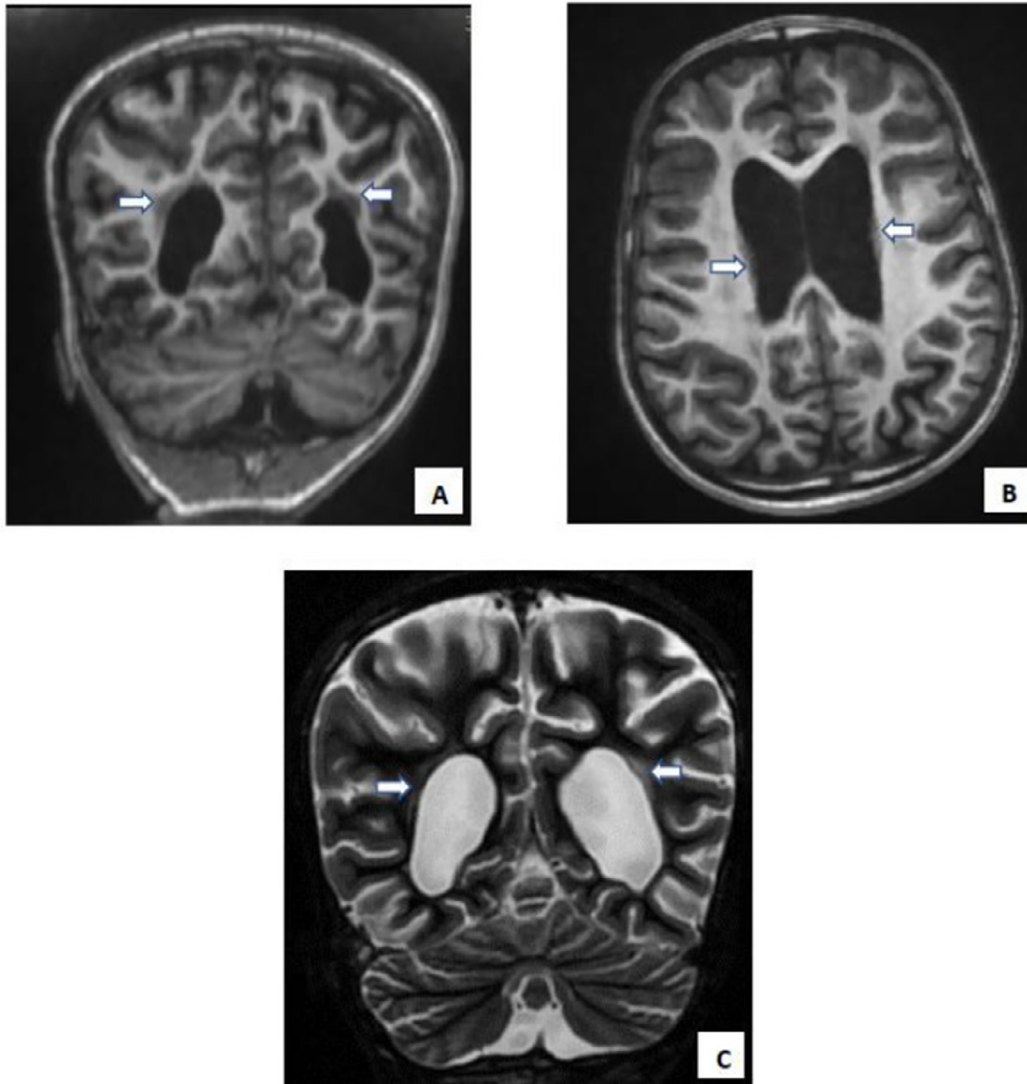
Brain MRI in 3DT1 axial and coronal sequence (A, B), T2 coronal sequence (C): presence of nodular lesions (large white arrows) in the periventricular area in T2 isosignal and T1 hyposignal, signal similar to that of the grey matter. Festooned aspect of the ventricular wall with triventricular hydrocephalus and cerebral atrophy.
